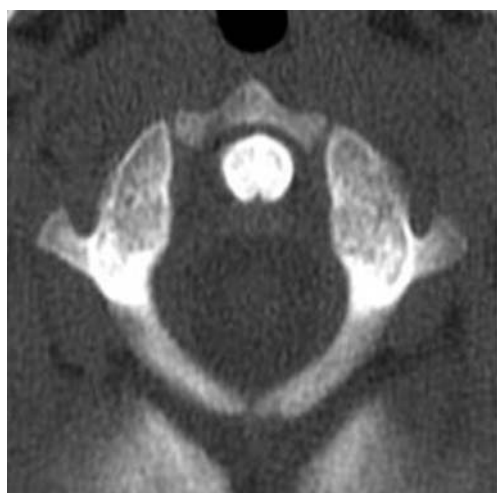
Axial CT image demonstrates clefts in the anterior and posterior arches of C1
